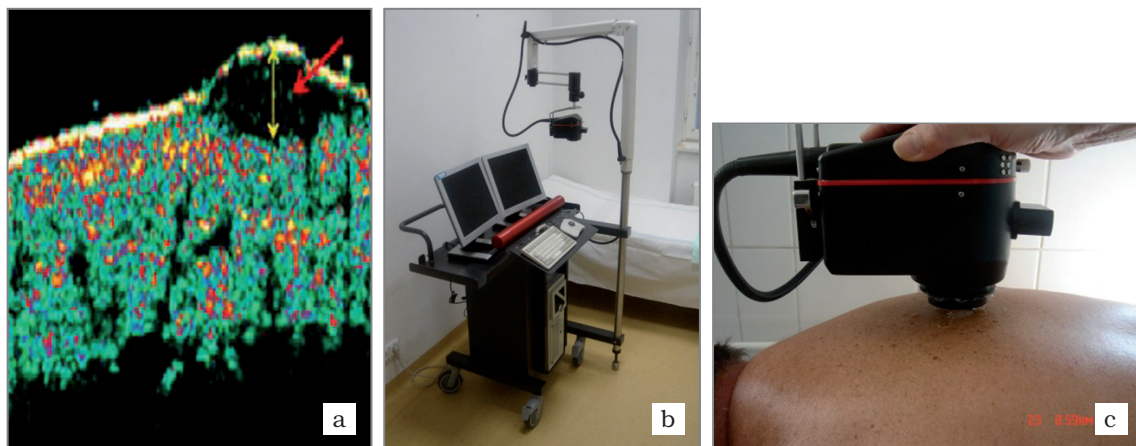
a, b, c Preoperative ultrasonographic image of melanoma using Dermascan C (b, c). Yellow double arrow represents melanoma thickness and the red arrow the hypoechoogenic melanoma tissue below epidermis (a)
